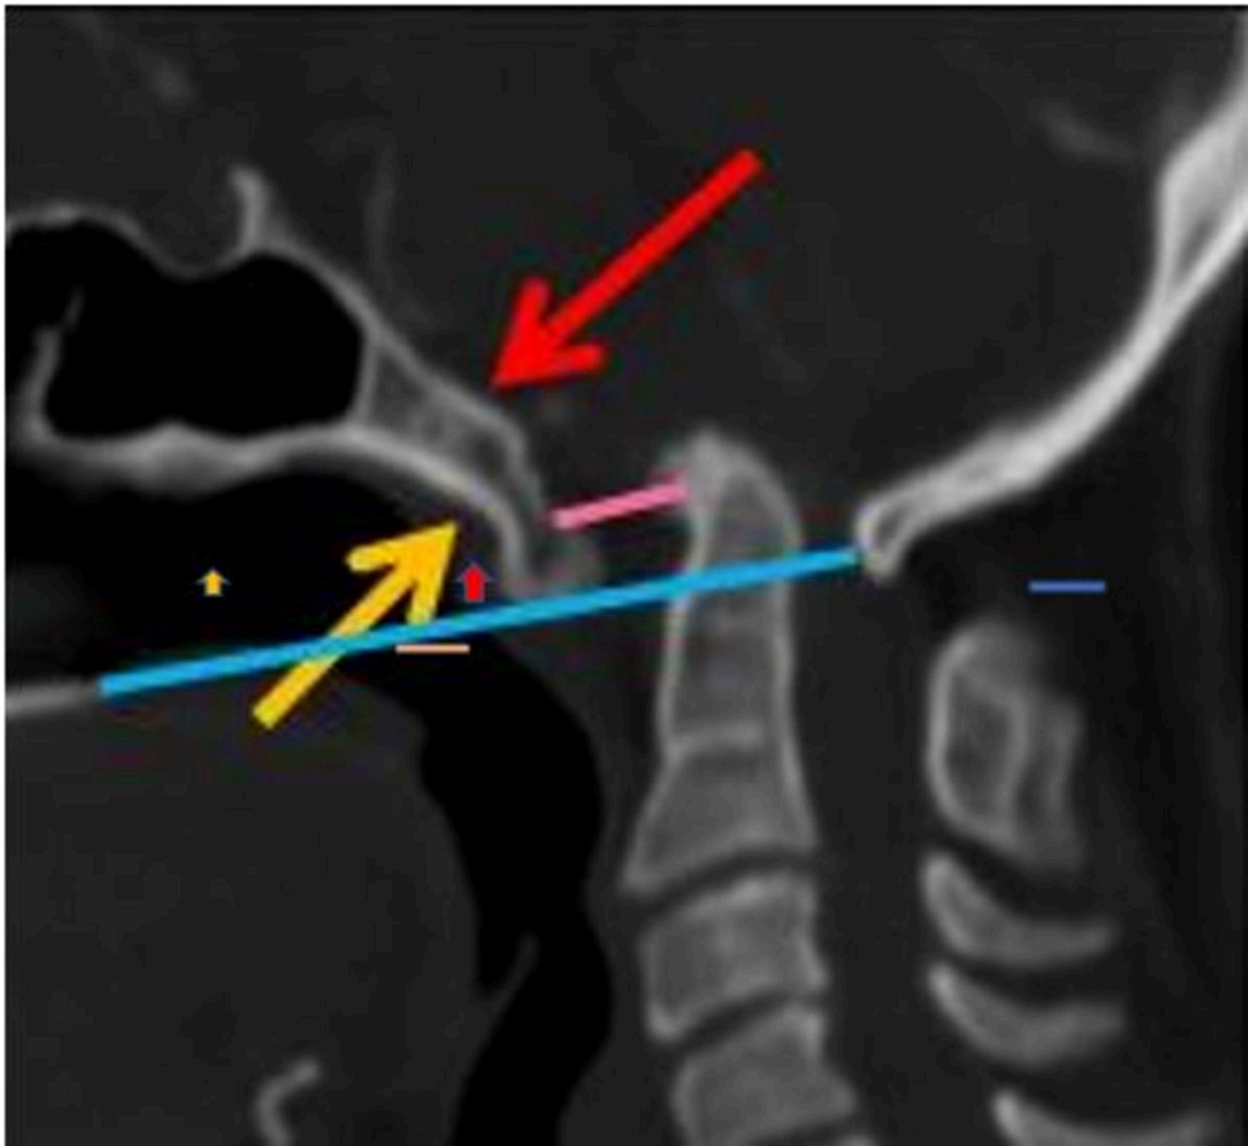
CT saggital section showing complete atlanto-occipital assimilation(yellow), short clivus(red), voilation of chamberlains line(blue)-basilar invagination and atlantoaxial dislocation(orange).
